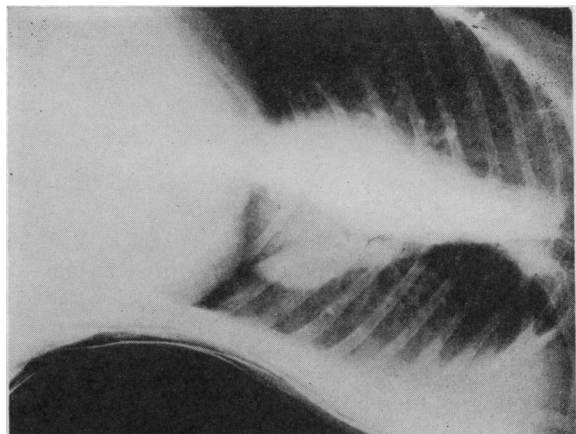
Roentgenogram showing crowding of vital organs in kidney operations position.
